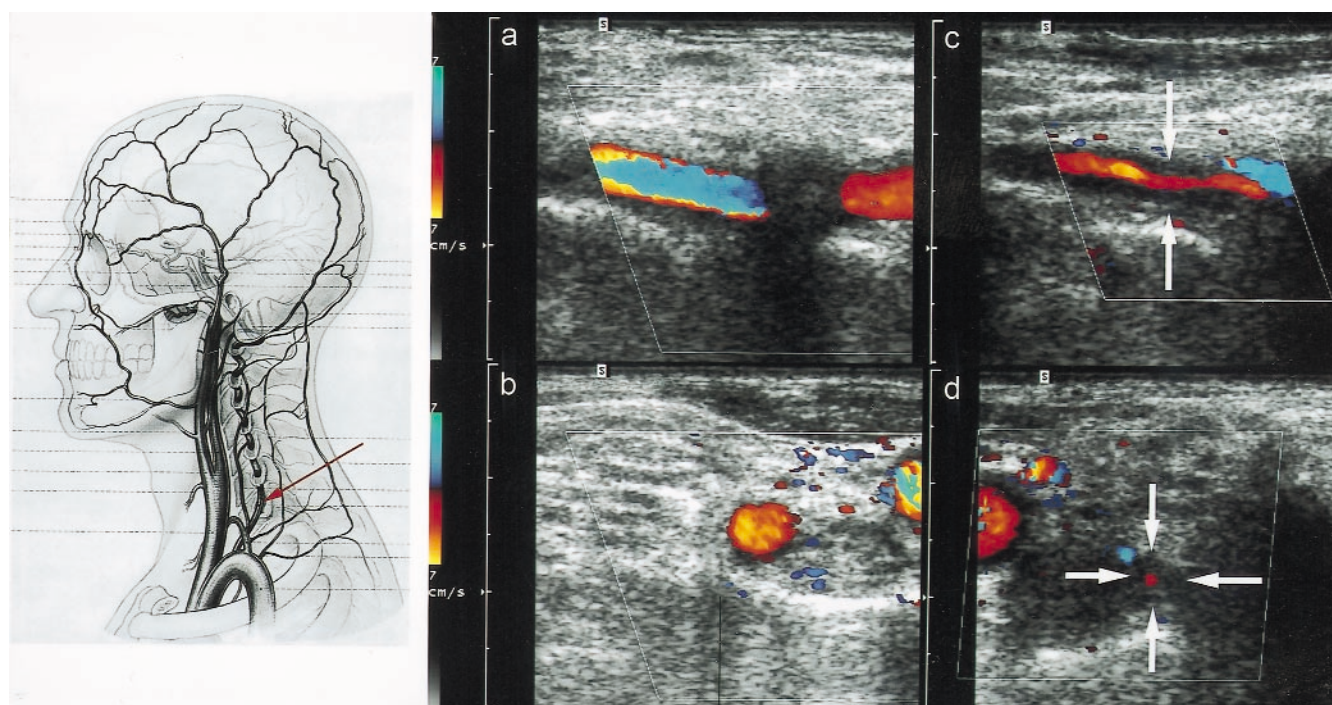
Color duplex sonography of the vertebral arteries in a 79-year-old patient with biopsy proven TA and mild vertebrobasilar stroke (Patient 2, Table 2). MRI angiography showed occlusion of the right vertebral artery: longitudinal and transverse sections of the V1 and V2 segments of the right vertebral artery (C, D). Severe hypoechoic concentric mural thickening of the V1 and V2 segments of the right vertebral artery (arrows). Left vertebral artery (A, B): normal findings.
